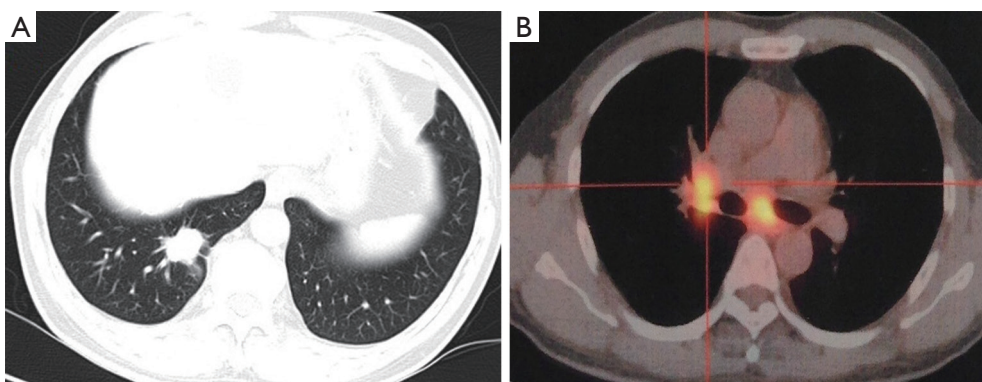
The medical image materials of the lungs on the first time the patient was diagnosed. (A) The computerized tomographic scan showed that the right lower lobe consisted of a nodule (2.5 cm × 1.8 cm); (B) the PET-CT image showed that the mediastinal lymph nodes and the right hilar lymph nodes enlarged and both were related with high SUV.
